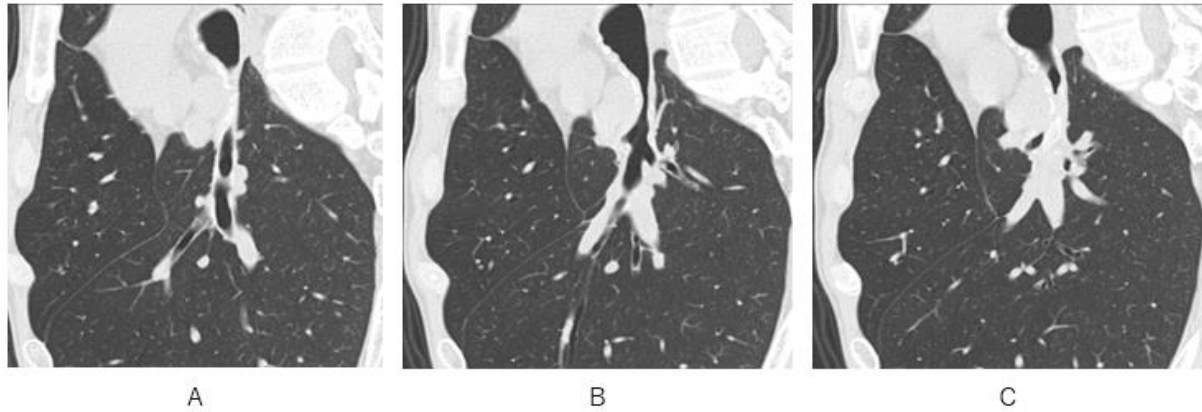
Stenosis of right main bronchus is depicted clearly on oblique sagittal CT.
